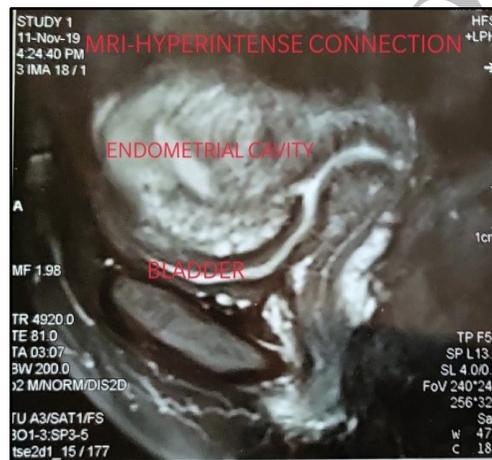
MRI showing the hyperintense communication tract between endometrial cavity and bladder cavity.
